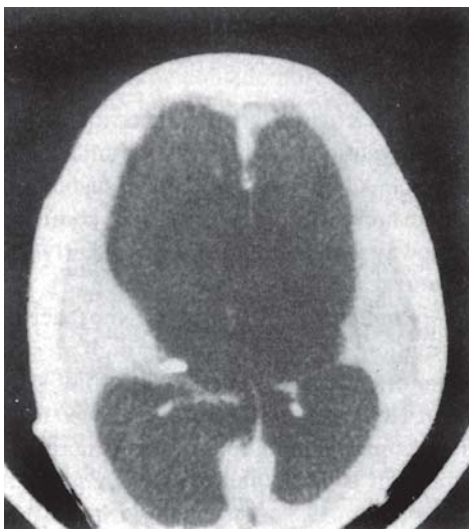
CT scan demonstrating grossly dilated ventricular system in tuberculous meningitis (TBM)
